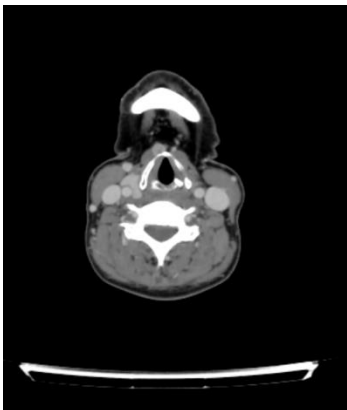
CT image of the patient
